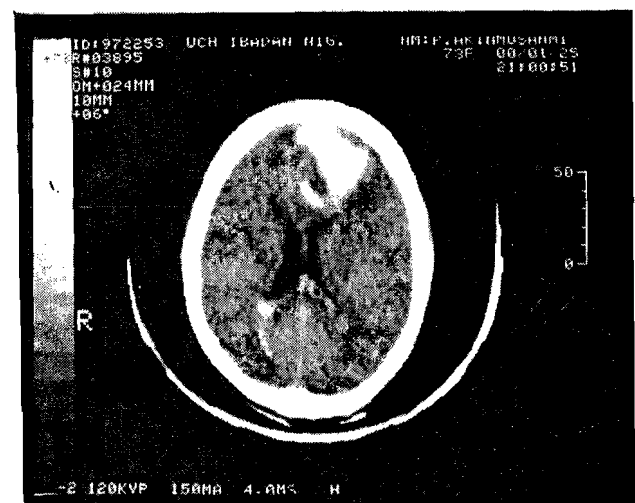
An unenhanced CT of the brain showing a hyperdense area of bleed in the left frontal lobe With associated intraventricular involvement.
